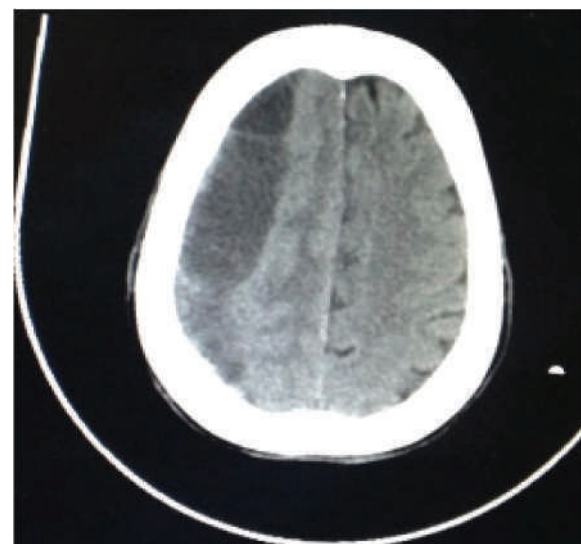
CT Brain (Plain) showing Right Frontotemporo-parietal Chronic Subdural Hematoma with Mass Effect and Midline Shift
